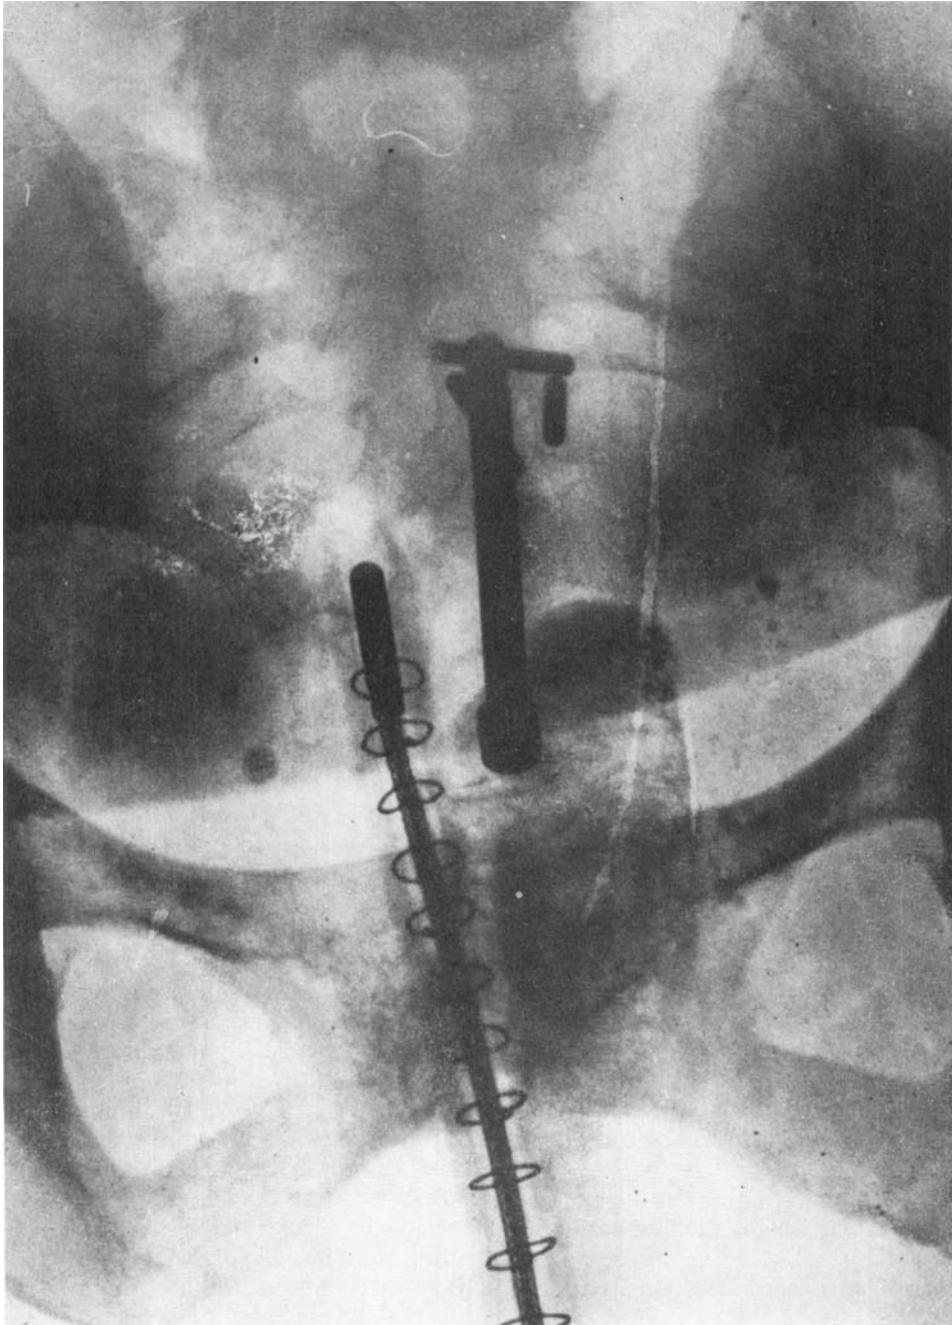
Radiograph showing the "fork" shaped radium applicator within the uterine cavity and the dosimeter within the rectum.
